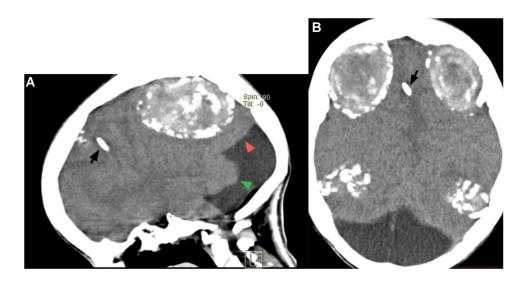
Noncontrast brain CT in sagittal (A) and axial (B) sections show vermian hypoplasia (green arrowhead in A), a midline cystic posterior fossa lesion communicating with dilated fourth ventricle, and elevated tentorium cerebelli (red arrowhead in A) suggestive of a Dandy-Walker malformation. A VP shut is seen anteriorly (black arrow in A and B).
